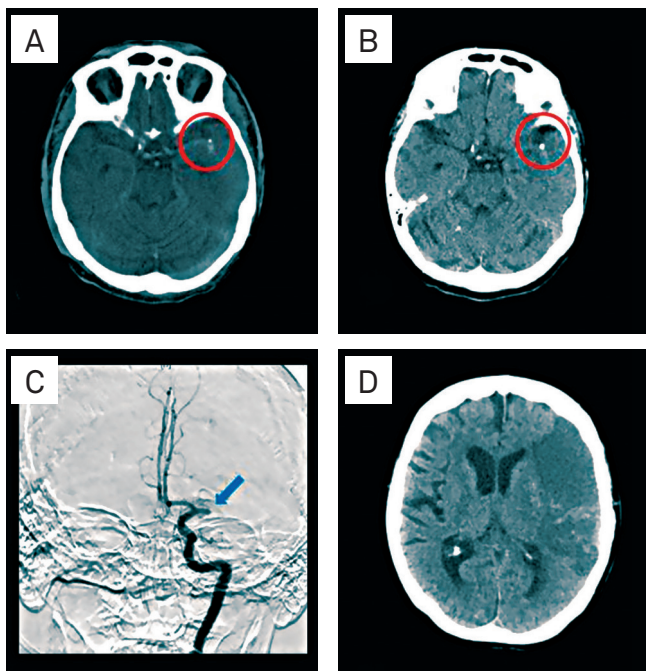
Computed tomography shows calcific embolus (circle) of the left middle cerebral artery (A), left middle cerebral artery calcific embolus three days after index event (B), and left internal carotid artery (ICA) injection shows occlusion (arrow) of M1 segment of the left middle cerebral artery (C). Computed tomography shows extensive left frontal-parietal area of hypoattenuation involving the superior division of the left middle cerebral artery.
